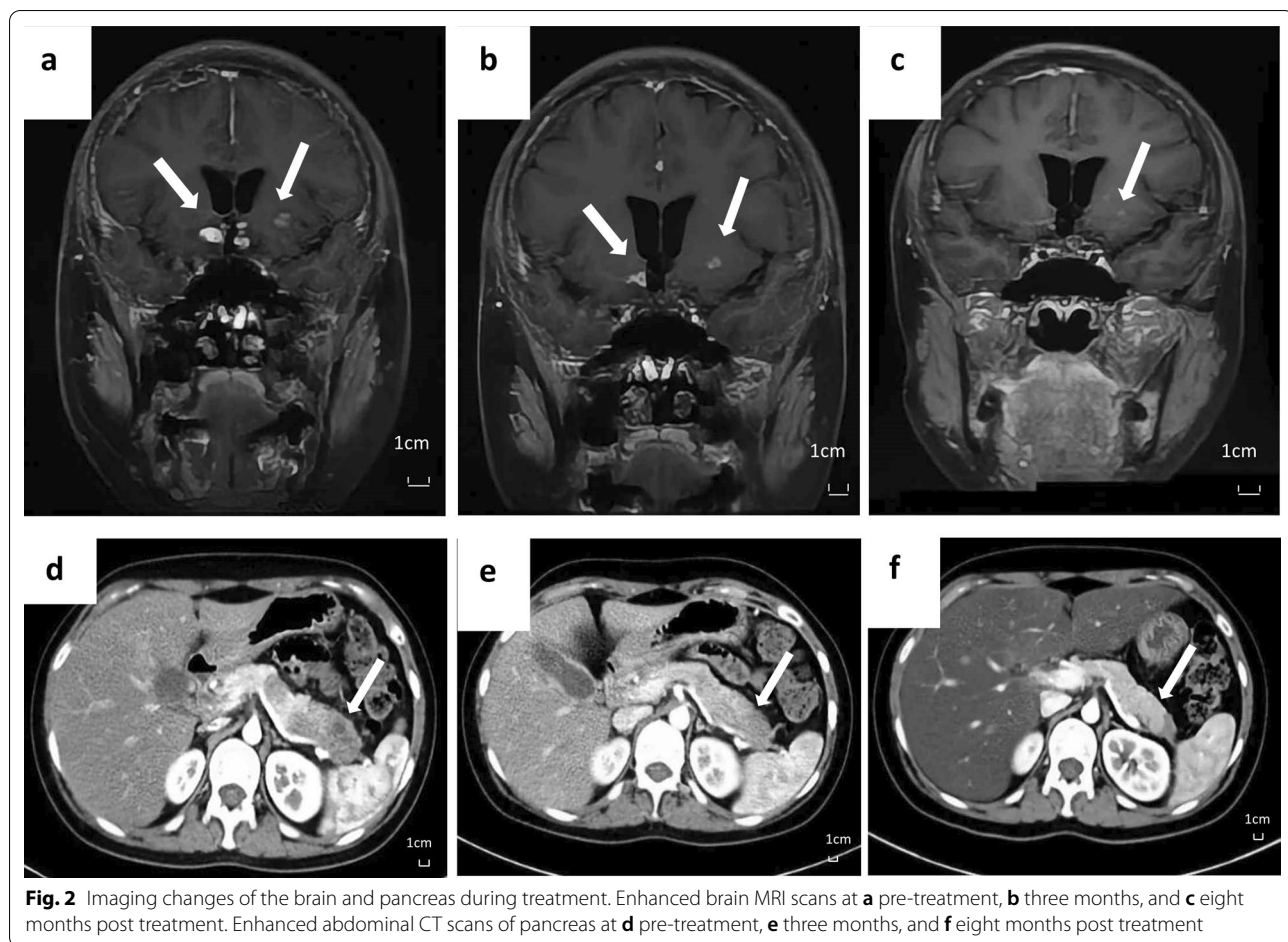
Imaging changes of the brain and pancreas during treatment. Enhanced brain MRI scans at a pre-treatment, b three months, and c eight months post treatment. Enhanced abdominal CT scans of pancreas at d pre-treatment, e three months, and f eight months post treatment
